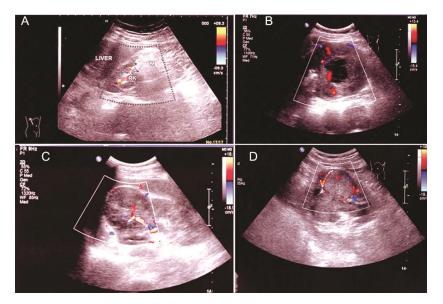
Ultrasound image of blood flow signals of different renal tumors. "A, B, C, D" correspond to "I, II, III, IV" blood flow signals, respectively.
